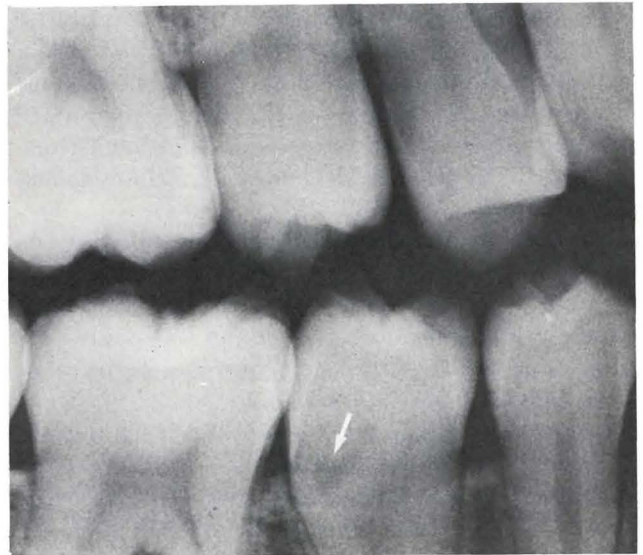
Bitewing radiograph with arrow demonstrating radiolucent lesion in cervical area.
